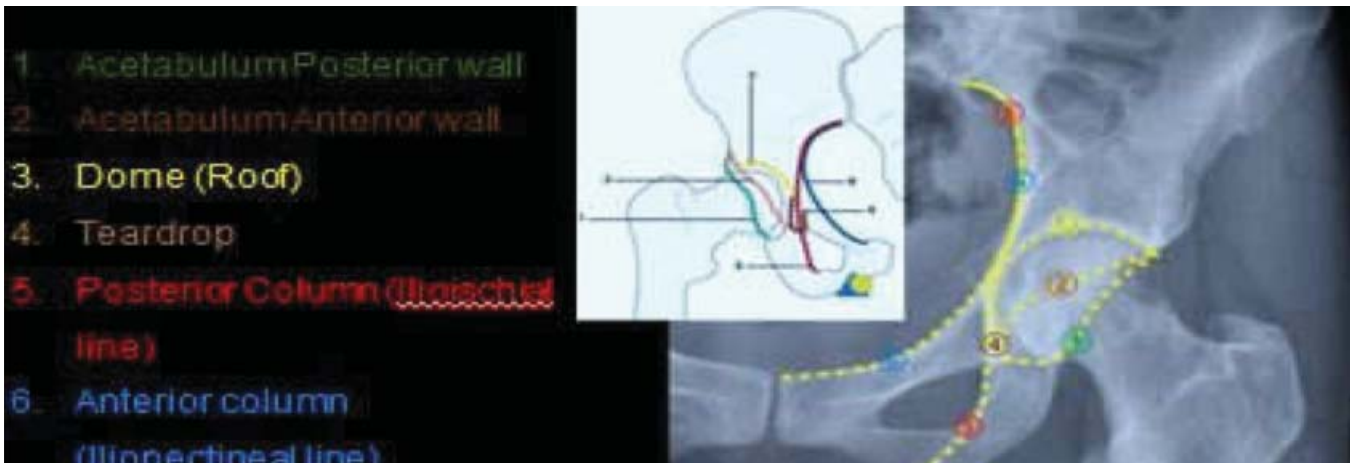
Anatomy and radiological lines on antero-posterior plain radiograph of pelvis.
